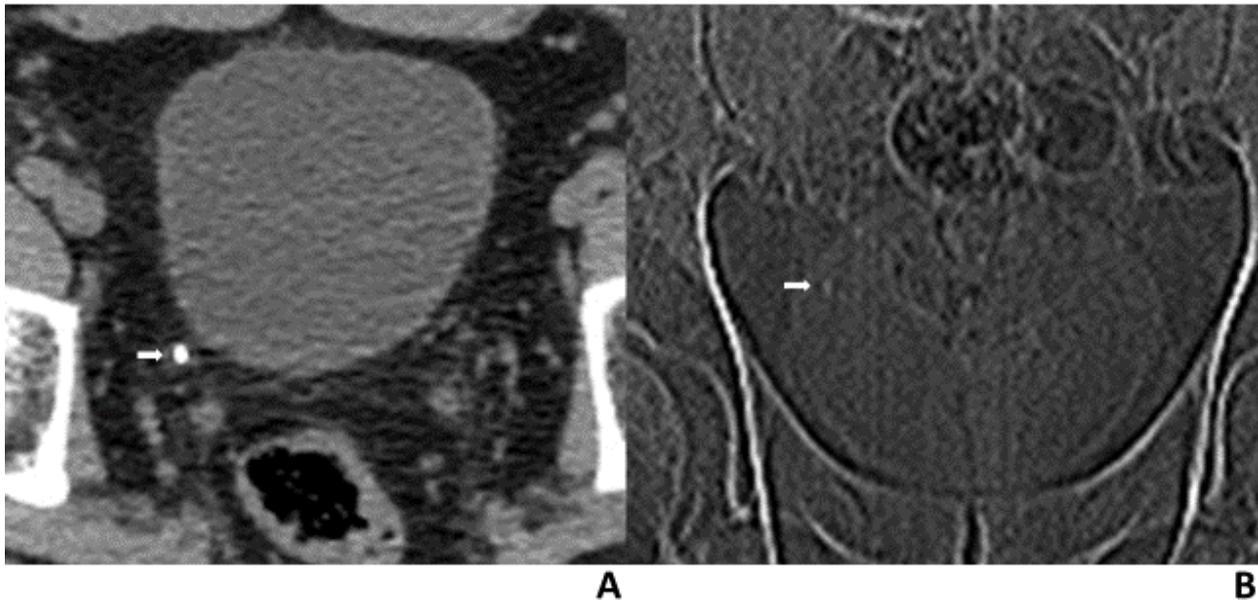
68-year-old man with right ureteral stone. A, axial CT scan shows a distal right ureteral stone (arrow) measuring 5 mm. B, CT scout radiograph shows right ureteral stone (arrow).
